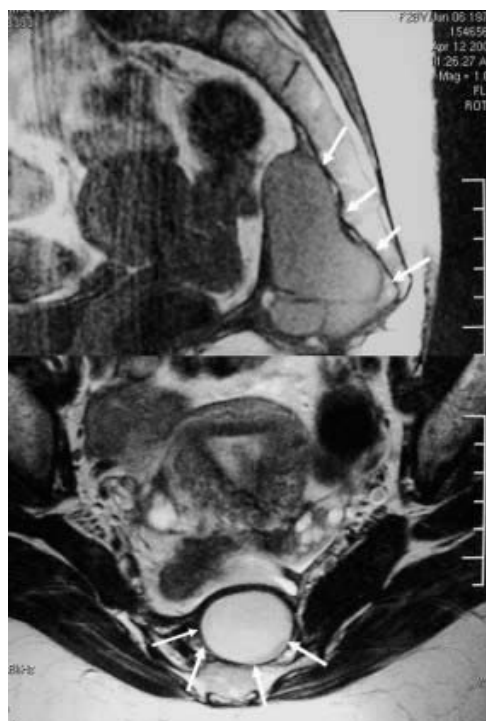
Magnetic resonance image of a recurrent cystic teratoma (arrows).
